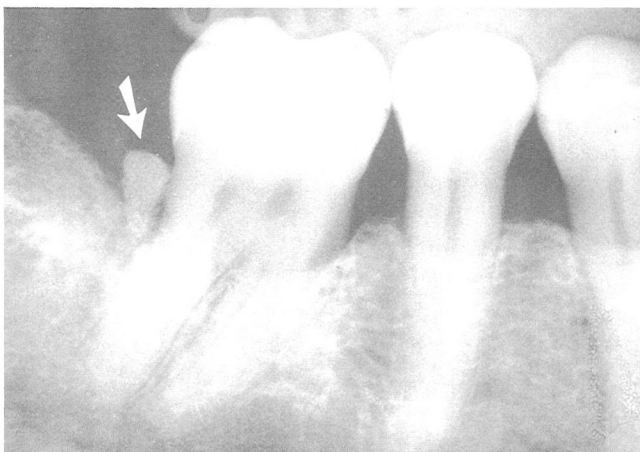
Radiograph of Case 2 at 4 months postoperative. The coronal portion of the implant has been trimmed after initial healing but there was exposure of the implant due to overfilling of the defect. Note radiographic changes in the apical portion of the implant consistent with osseous infiltration.
